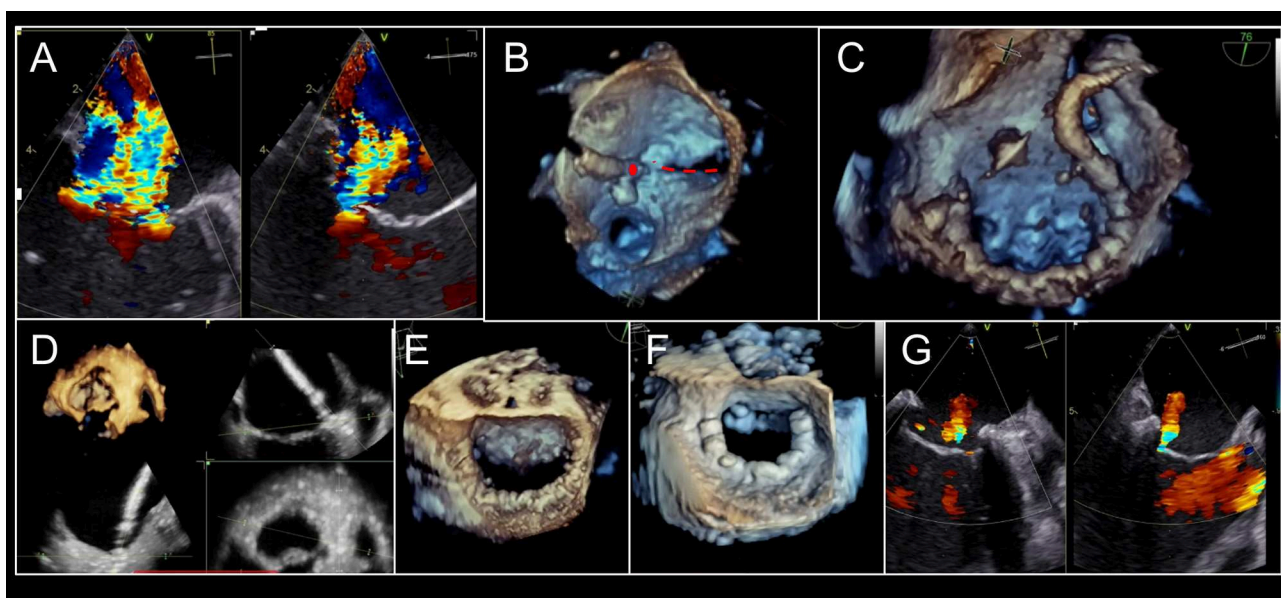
Intra-procedural echocardiographic guidance for cardioband procedure. (A) Severe, functional mitral regurgitation is shown in biplane, color Doppler imaging. (B) After transseptal puncture, the first anchor (red circle) is implanted adjacent to the lateral commissure (red-dashed line). (C) Cardioband implantation continues adjacent to P3 scallop. (D) At each anchor implantation, multiplane 3D imaging is helpful to locate position of anchor insertion within the mitral annulus, with adequate distance from leaflet. (E). Completed Cardioband pre-cinching is shown. (F) After cinching, annuloplasty reduction is achieved. (G) Post-implant mitral regurgitation appears mild by qualitative assessment. 3-dimensional color Doppler multiplanar reconstruction may be used to planimeter vena contracta area. Images courtesy of Dr. Florian Deuschl.
